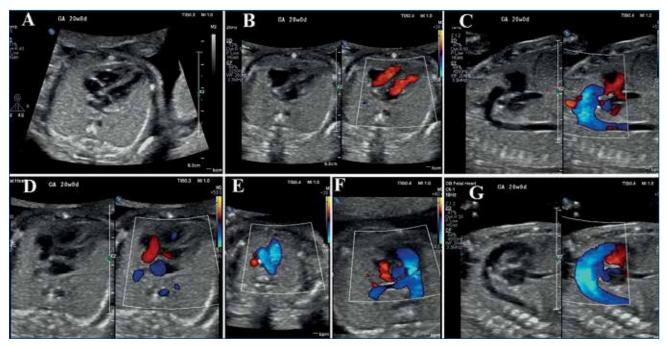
Fetal heart evaluation. A: Four-chamber view: right ventricle with moderator band, left ventricle giving the apex of the heart, left atrium with pulmonary veins, *crux cordis*, foramen ovale, descending aorta and adjacent hemiazygos vein. B: Grey-scale and color Doppler flow evaluation of the four-chamber plane, atrioventricular flows and intact atrioventricular septum. C: Aortic arch. Three head and neck vessels arise from the aorta. Descending aorta. D: Left ventricular outflow tract (aortic root). E: Three-vessel view with the confluence of the ductal and aortic arterial arches and superior *vena cava* present at the right. F: Right ventricular outflow tract, with pulmonary trunk branching in the axial plane with no turbulences across the pulmonary valve and right direction of flow down the *ductus arteriosus*. G: Ductal arch. Doppler assessment demonstrates flow away from the heart with no obvious turbulence or reverse flow and no tributaries directed towards the neck
